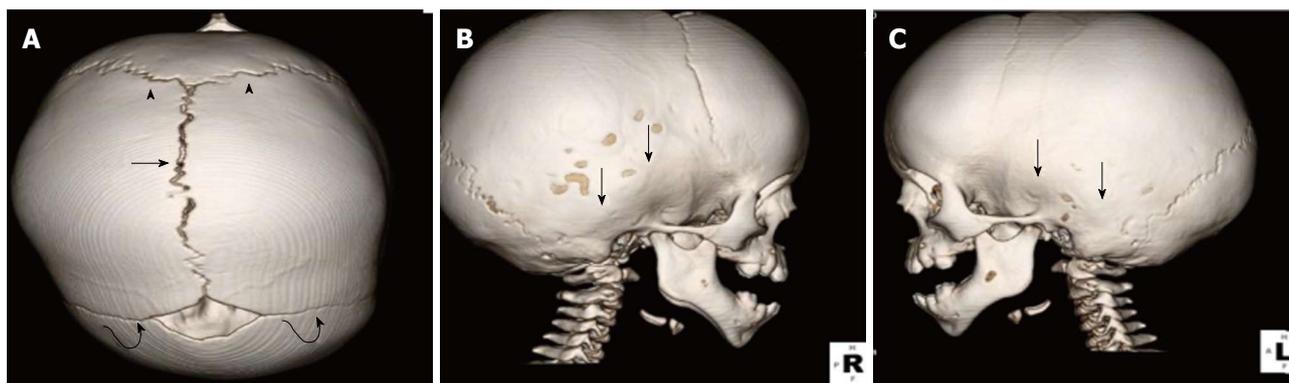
3 D computed tomographic image. A: Of the skull demonstrating normal appearance to the coronal (curved arrows), sagittal (straight arrow), and lambdoid sutures (arrow heads); B, C: Of the cranium demonstrating bony bridging of bilateral squamosal sutures consistent with premature craniosynostosis. The approximate region of the normal squamosal sutures is indicated by straight arrows.
